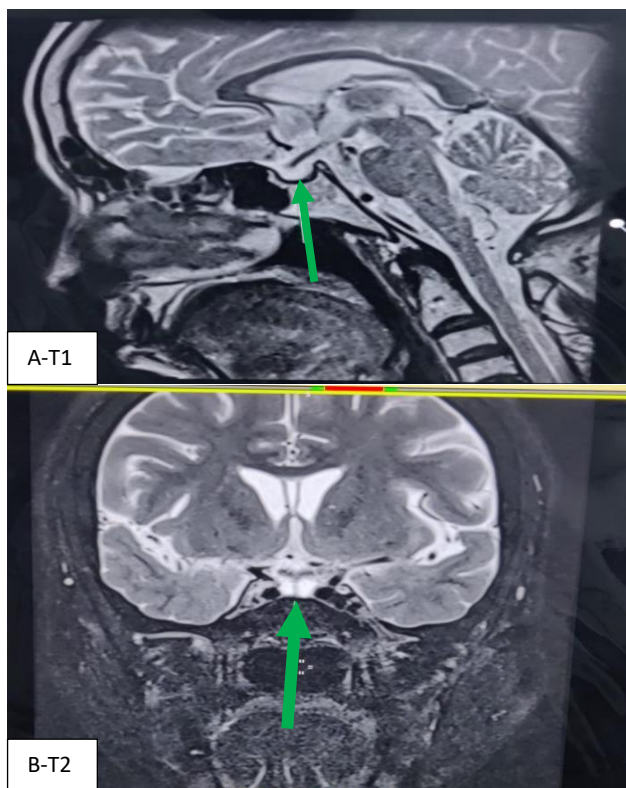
(A and B): An axial view of a T1-weighted magnetic resonance scan of brain. A green arrow denotes pituitary's flattened position. T2-Coronal view region-CSF filling empty Sella.
